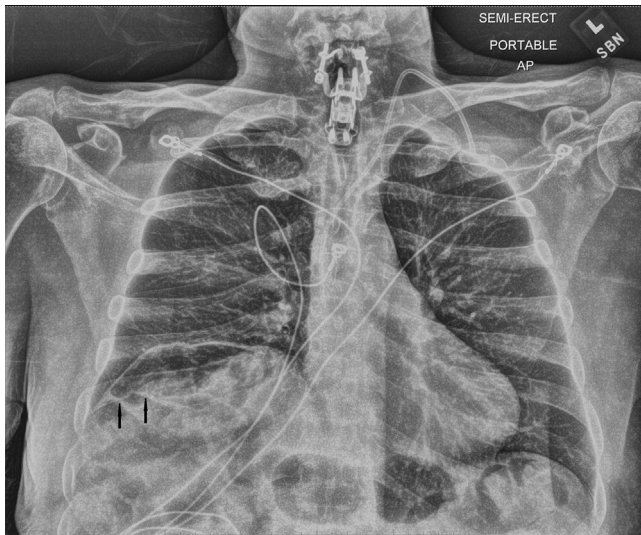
Plain film of the chest with possible pneumoperitoneum (wide black arrow).
